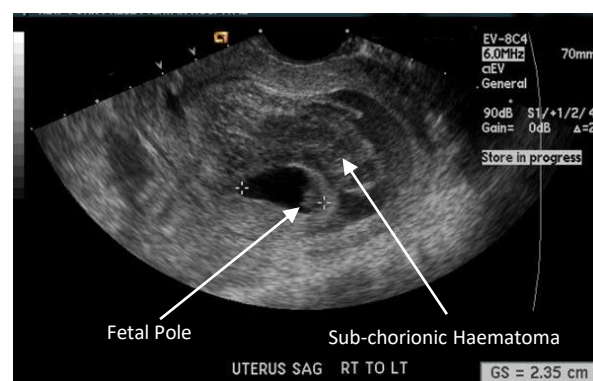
Sonographic appearance of sub-chorionic haematoma in a singleton pregnancy <sup>(3)</sup>
